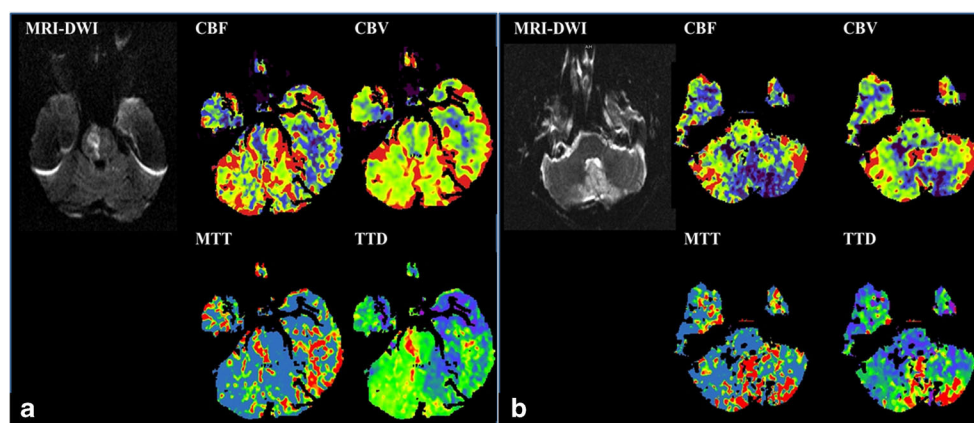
a Ninety-two-year-old female presenting with dysarthria, dysphagia, and a left-sided hemiparesis. CTP was performed 90 min after symptom onset and showed a right-sided paramedian hypoperfusion of the pons with a mismatch between CBF and CBV. CTA revealed a thrombotic occlusion of the basilar artery. The patient received iv-thrombolysis immediately after multimodal CT imaging. The ischemic lesion on follow-up MRI reveals a right paramedian pons
